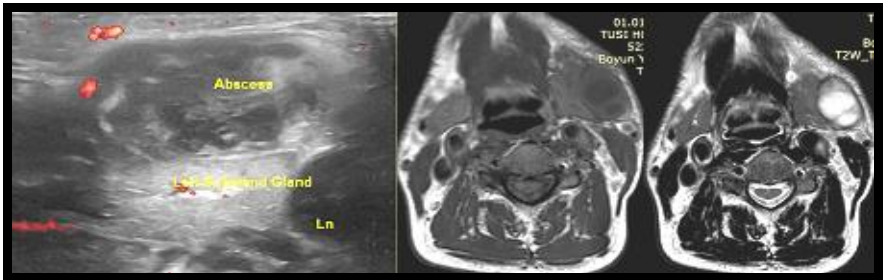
V. I., male, 53 years old, a/c 0012. Heterogeneous, mixed echogenic, nonvascular fuzzy and smooth-contoured abscess in the left submandibular gland in USG with ED. Infiltration into the surrounding gland tissues and reactive lymphadenopathy. Pathological foci of cystic type, T1 hypo-, T2 hyperintensive (abscess), in which unevenly located thick capsules and septa inside the abscess are observed on MRI.
